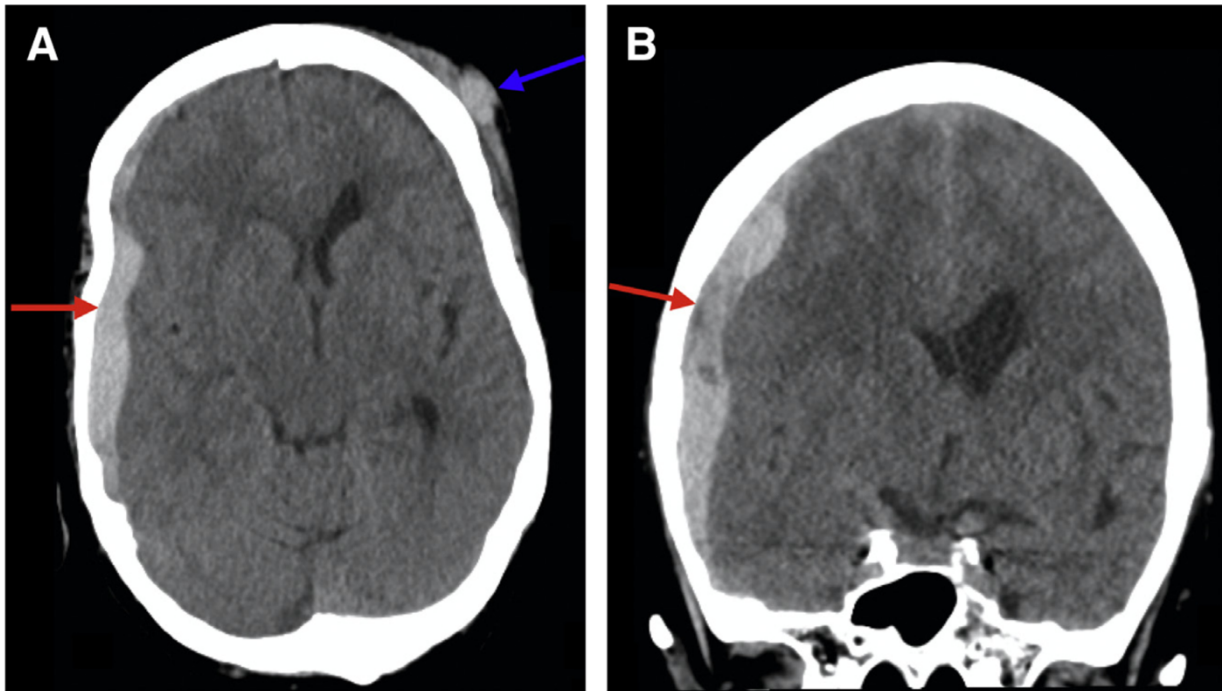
Axial (A) and coronal (B) non-contrast CT of traumatic acute right convexity subdural haematoma (red arrows). The blue arrow highlights a left frontal subgaleal haematoma indicating the contrecoup nature of the subdural haematoma. [Reproduced from Carroll et al with permission.][37]
